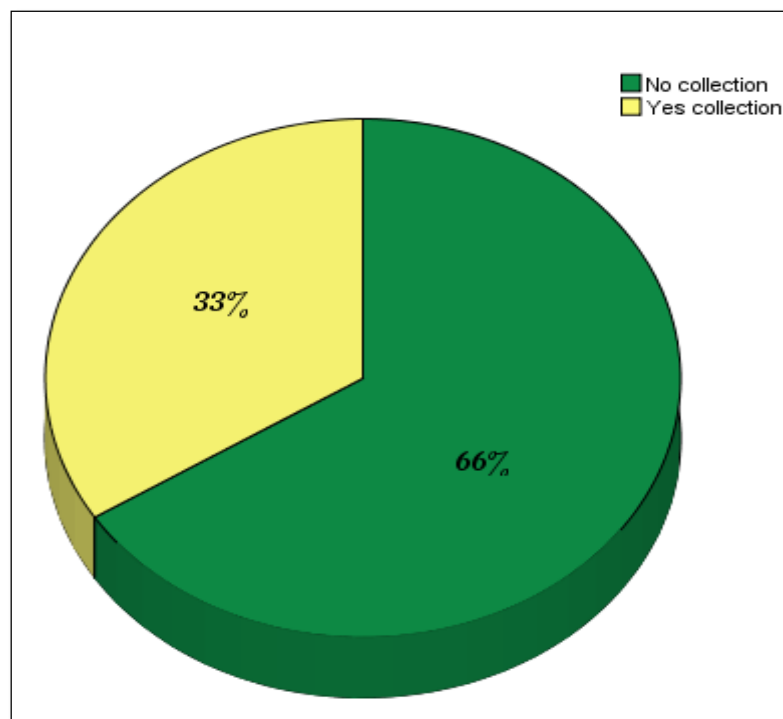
Frequency distribution of ultrasound finding for collection of fluid
